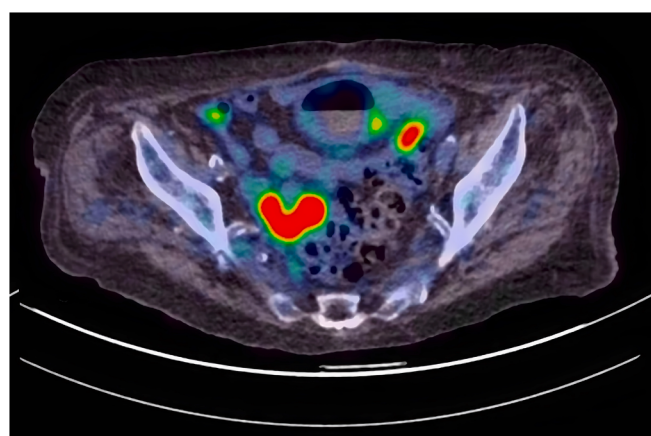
Axial positron emission tomography–computed tomography image showing a right parasigmoid pelvic abscess with intense fluoro-2-deoxyglucose uptake (standardized uptake value maximum 11.1) and a heart-shaped morphology. Colors indicate fluoro-2-deoxyglucose uptake intensity. Warmer colors indicate higher metabolic activity, and cooler colors indicate lower activity.
